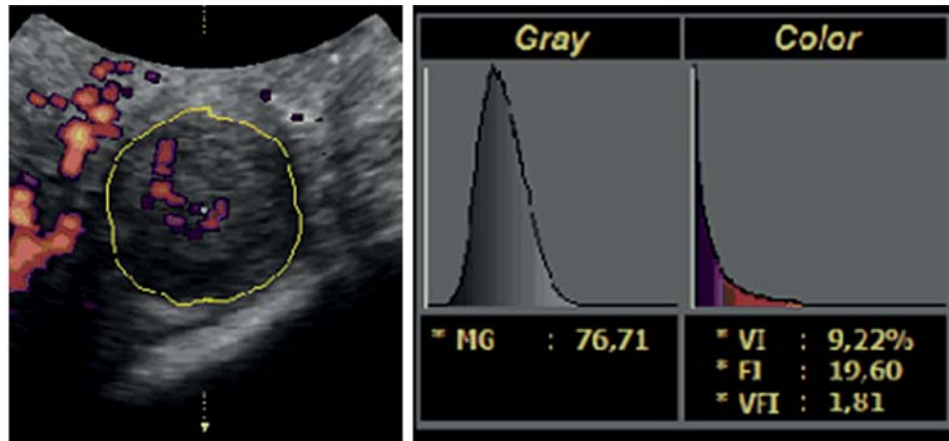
Measuring Vascular parameters (indices) with 3D Power Doppler. After volume acquisition, vascular indices can be obtained using the additional “histogram” function. Automatically, the vascular indices (VI, FI, VFI) are calculated of the selected volumes. VI=vascular index (% colour voxels), FI=flow index (mean intensity colour voxels), VFI= vascular flow index (average colour value of all grey and colour voxels)
